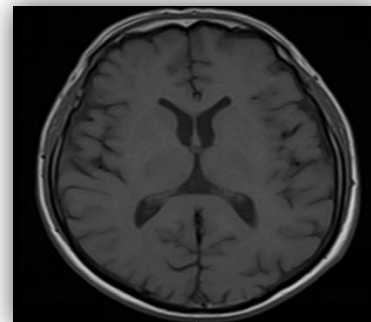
MRI image of the worker exposed to Mn without T1W hyperintensity.
